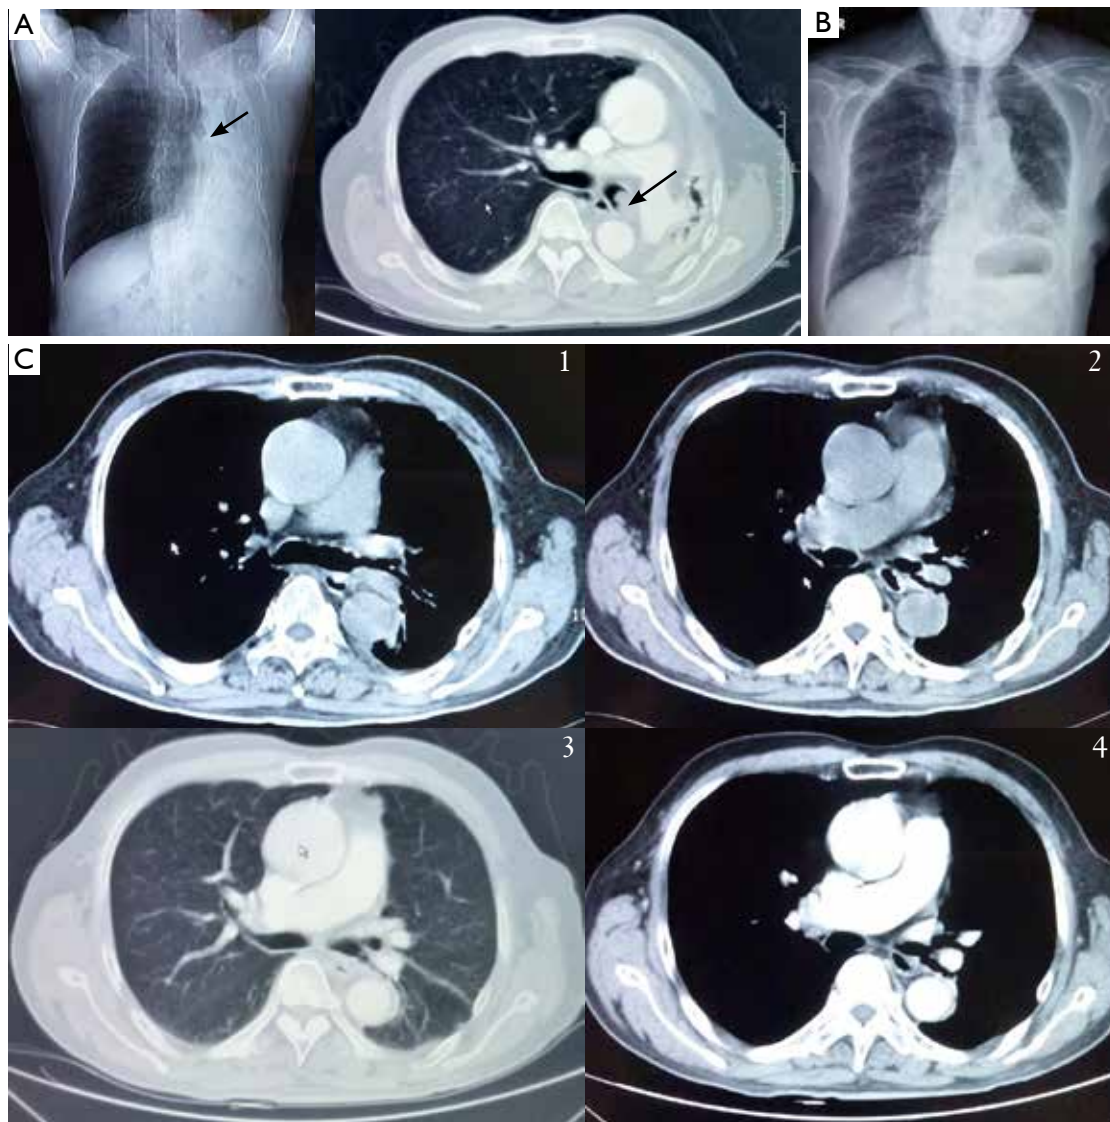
(A) Computed tomography scan showed the lesion located at the end of left main bronchus, between the opening of upper and lower bronchus; (B) chest radiography at the first day of postoperation showed the upper and lower lobes of left lung were both full recruitment; (C) computed tomography after 3 weeks of postoperation showed anastomotic healing well, and the opening of upper and lower lobe bronchus were smooth.
